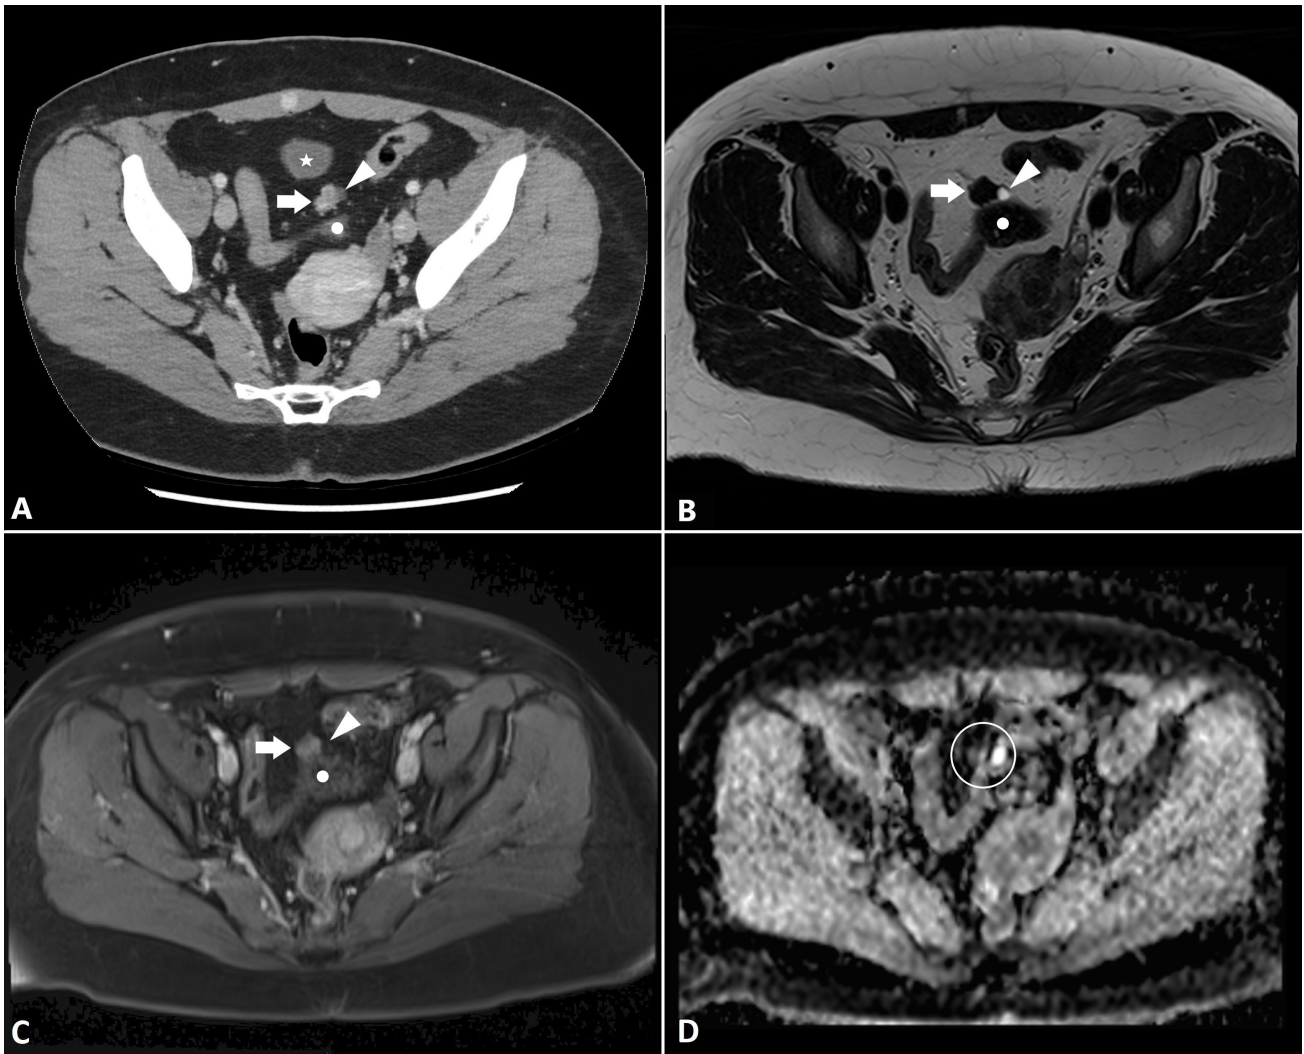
Imaging features of disseminated peritoneal leiomyomatosis. (A) Pelvis computed tomography scan with intravenous contrast medium on sagittal plane (venous phase): a soft tissue formation of 20 × 13 mm characterized by mild contrast enhancement (white arrow) and a sub-centimetric cystic component (white arrowhead) localized between the bladder roof (star) and the sigmoid colon (dot). (B) Pelvis MRI scan on the same plane (T2-weighted sequence), better representing the marked hypointensity of the nodule (white arrow) and the contextual thin-walled cyst (white arrowhead), both of which are still clearly separated by the sigmoid colon (dot). (C) During dynamic contrast-enhanced MRI sequences, the disseminated peritoneal leiomyomatosis (DPL) nodule shows mild early enhancement (arrow), while the cystic component remains completely avascular (arrowhead), and both the nodule and the cystic component show different enhancement from the nearby sigmoid colon (dot). (D) Apparent diffusion coefficient map of the same section highlights the absence of increased restriction of water diffusion in the DPL nodule (circle).
